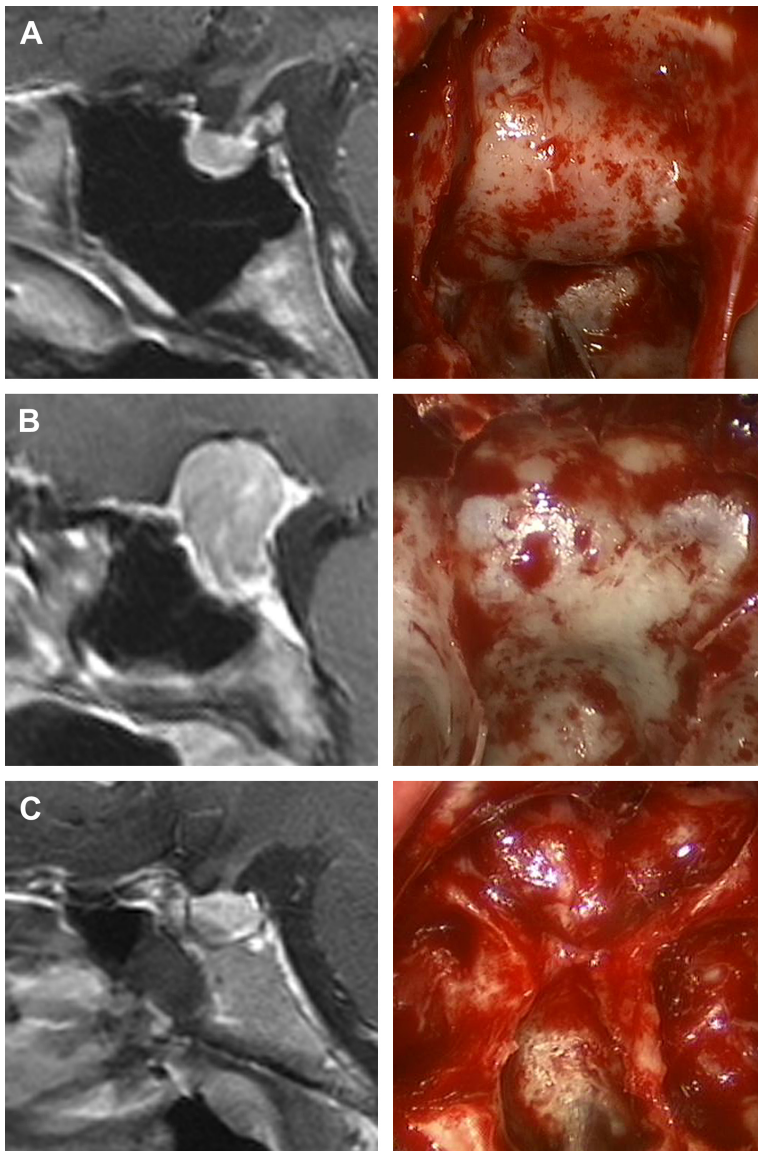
Variations in sellar phenotypes on MRI. (A) Prominent sellar floor. (B) Curved sellar floor. (C) Flat sellar floor or conchal sphenoid phenotype. (From Zada G, Agarwalla PK, Mukundan S, et al. The neurosurgical anatomy of the sphenoid sinus and sellar floor in endoscopic transsphenoidal surgery. *J Neurosurg* 2011;114(5):1319–30; with permission.)
